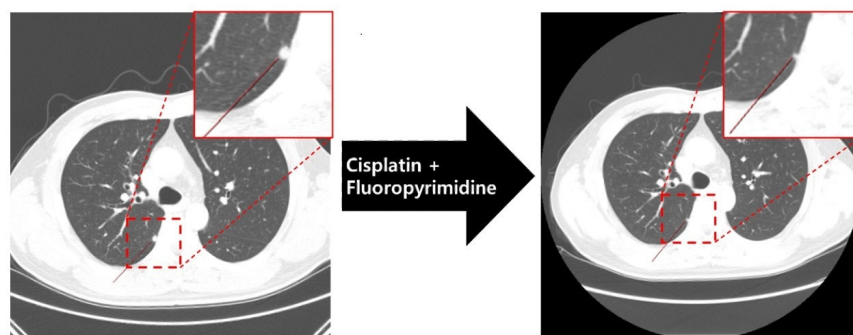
Chest CT showing tumor response after cisplatin and fluoropyrimidine chemotherapy
